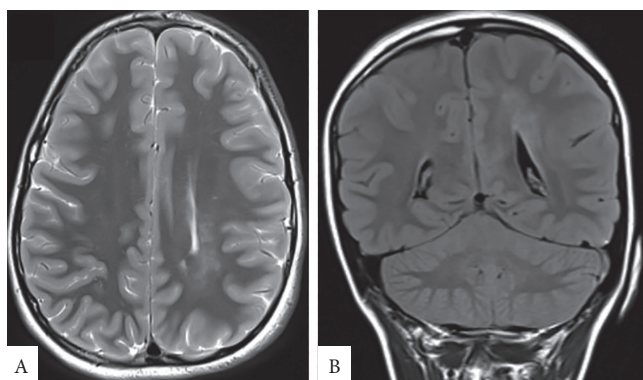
(A) Axial and (B) coronal view of left hemimegalencephaly with periventricular gliotic lesions - 3 T brain MRI
